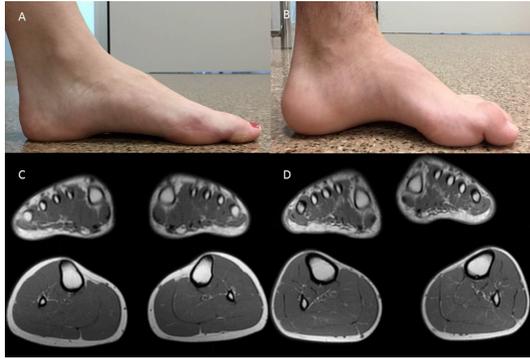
Clinical pictures and muscle MRI (T1 weighted images shown). A Mild pes cavus of patient II:1. B Moderate pes cavus with hammer toes of patient II:2. C Muscle MRI of patient II:1 showing no fatty replacement at feet and calf level. D Muscle MRI of patient II:2 showing no significant abnormalities at either feet or calf level.
